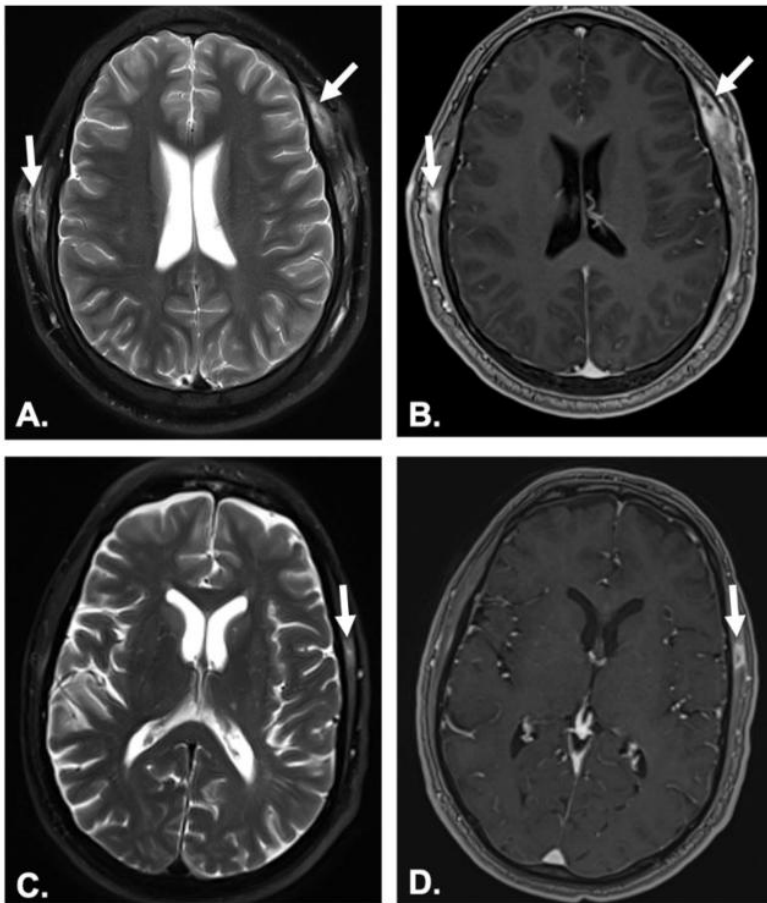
Axial T2-weighted (A, C) and gadolinium-enhanced T1-weighted (B, D) images obtained in 2 different patients following recent surgery demonstrate T2-hyperintense, enhancing temporalis muscle abnormalities (arrows, A-D) initially interpreted as suspicious for metastasis but which spontaneously resolved on follow-up imaging. Patient 1 (A and B) recently underwent suboccipital craniotomy, and Patient 2 (C, D) recently underwent cervical laminectomy, both for tumor resection and both aided by the Mayfield skull clamp.
